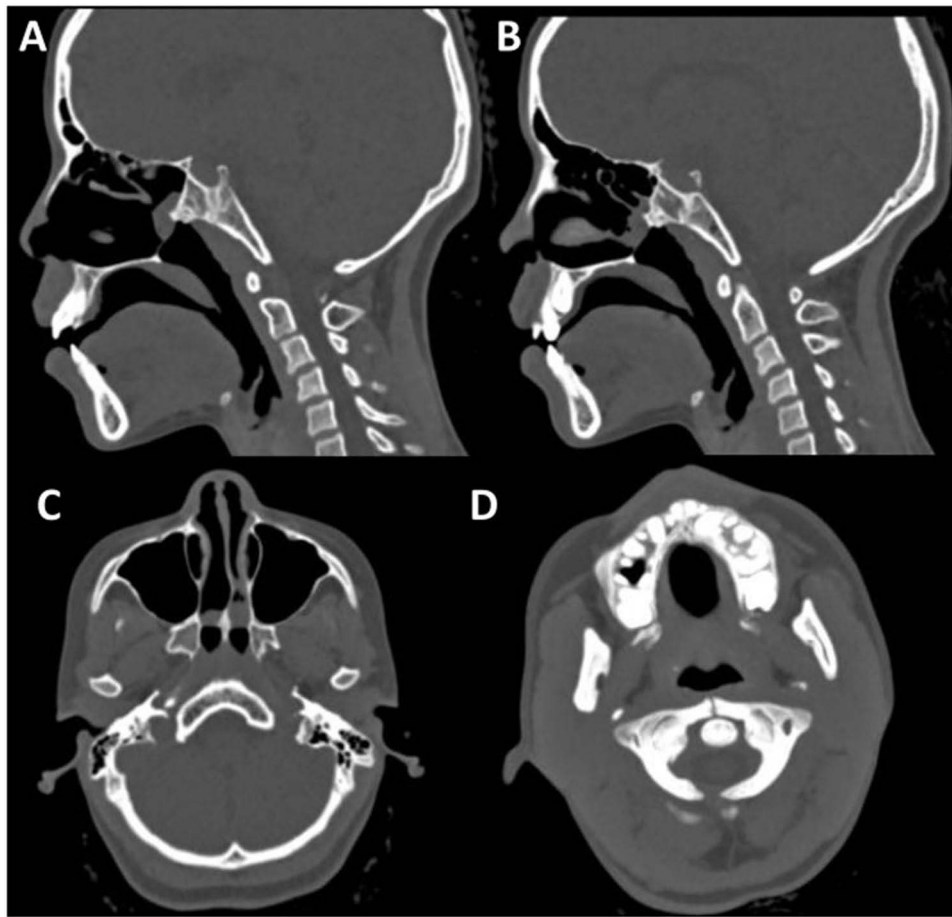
Sagittal (A and B) and axial (C) CT images of the paranasal sinuses in bone window settings demonstrate thickening of the vomer (in C), medialization of the pterygoid plates (in C) and membranous bridging of the remaining choanal opening. Minimal retained secretions are seen in the nasal cavities. A lower axial section (D) shows bipartite atlas, in which both anterior and posterior arches of CI are unfused.
